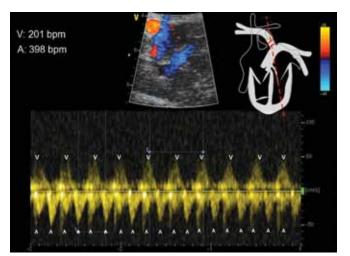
Atrial flutter is diagnosed with simultaneous pulmonary vein and artery Doppler investigation
